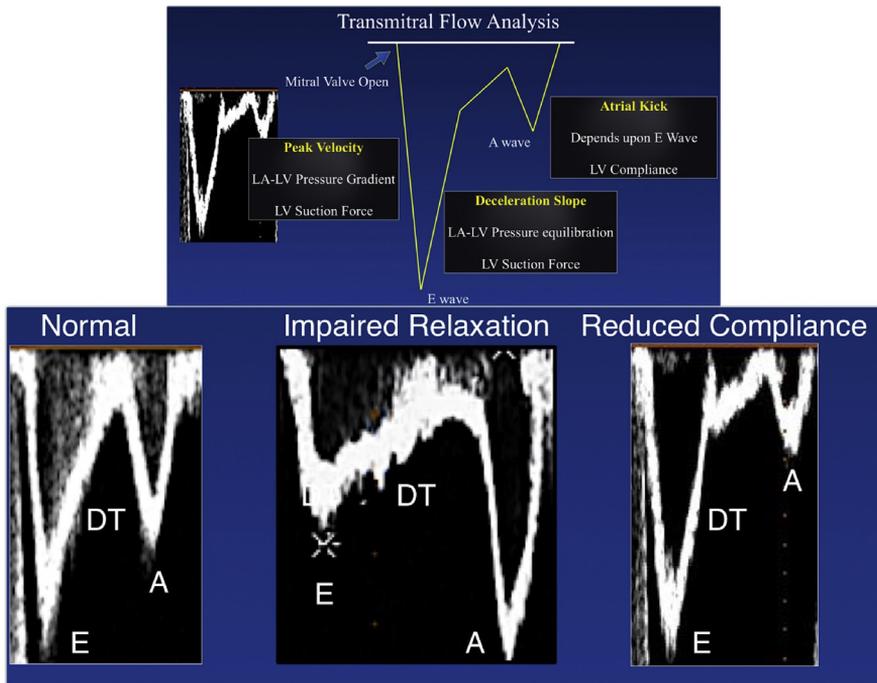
Typical transmitral pulsed wave Doppler pattern. Top panel, Graphical description of the measurement of peak velocities and gradients. Bottom panel, Actual pulsed wave pattern in normal, impaired compliance, and reduced compliance. E wave = rapid filling phase, A wave = atrial kick, DT = Deceleration time.
